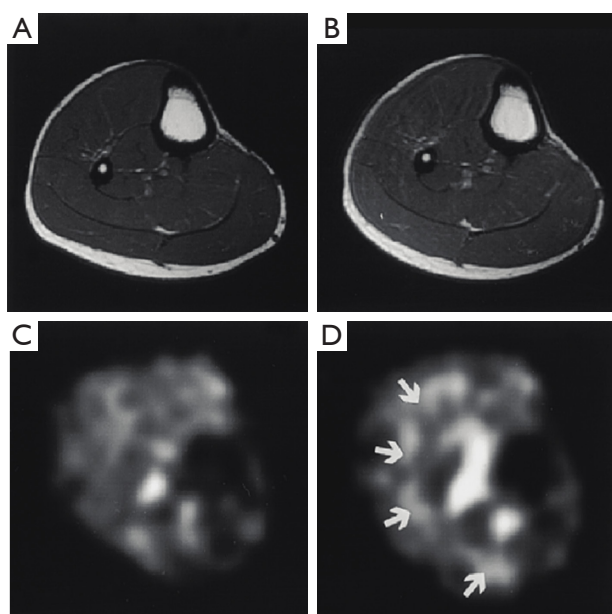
Weber *et al.* acquired images of a 10-year-old boy with Duchenne muscular dystrophy (A-D) and a 16-year-old healthy volunteer (E-H).  $^{23}\text{Na}$  IR (C) and tissue sodium concentration (TSC)  $^{23}\text{Na}$  MRI (D) show elevated levels of sodium in the soleus muscle of the boy with muscular dystrophy compared to the normal volunteer. A greater difference in sodium concentration is seen using the  $^{23}\text{Na}$  IR over total TSC suggesting the greater difference being in intracellular sodium concentration (88). Copyright 2011 Wolters Kluwer Health, Inc. Used with permission from Weber MA, Nagel AM, Jurkat-Rott K, *et al.* Sodium ( $^{23}\text{Na}$ ) MRI detects elevated muscular sodium concentration in Duchenne muscular dystrophy, *Neurology* 2011;77:2017-24.
